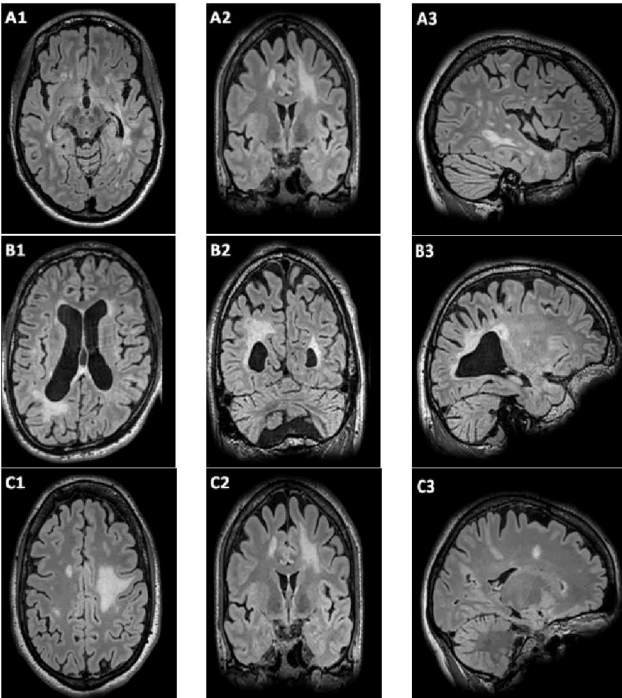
Some MRI scans with MS lesions in the UMCL MS dataset. A1, B1, C1 show the scanning in the axial plane of the MR images, A2, B2, C2 coronal plane and A3, B3, C3 in the sagittal plane
